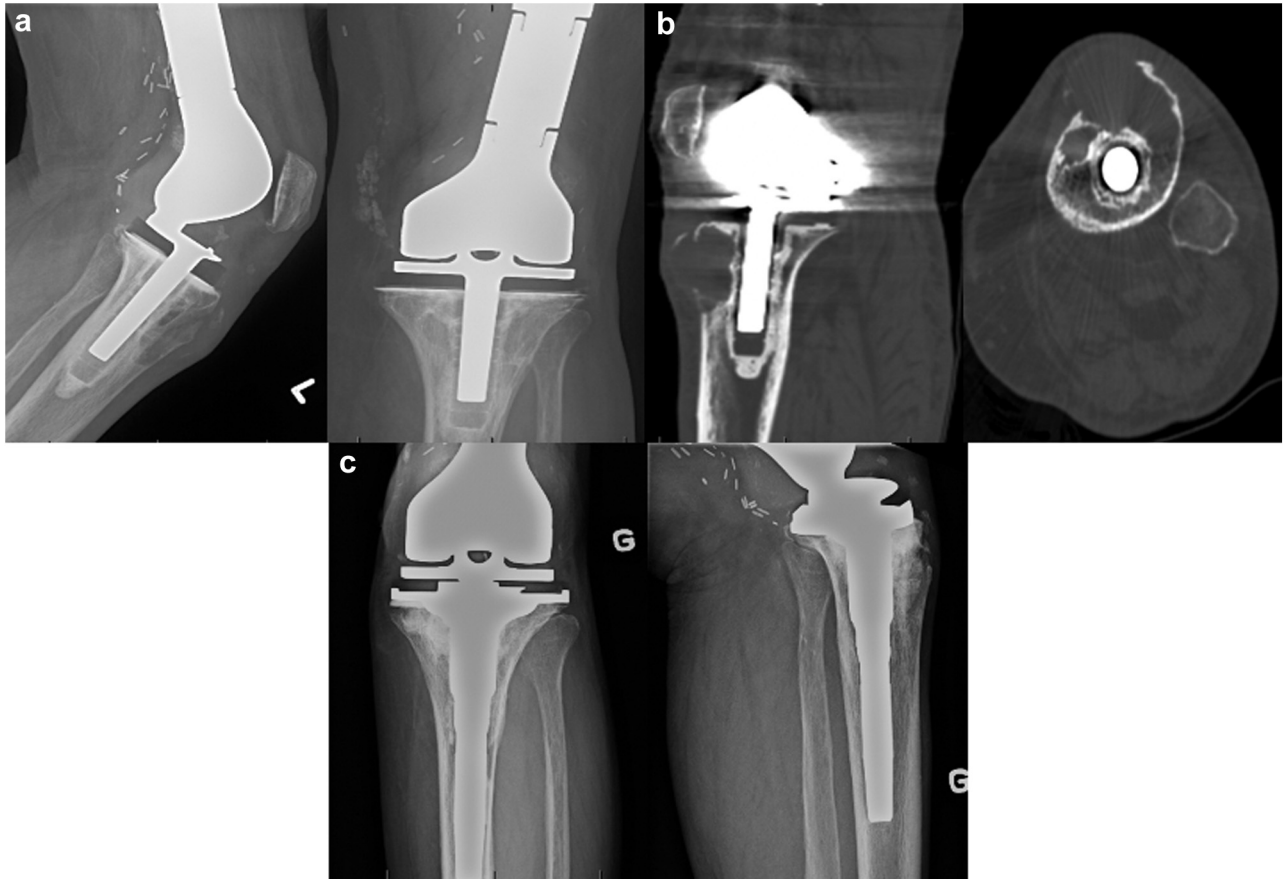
Patient B, left knee. (a) Plain radiographs demonstrating a nondisplaced fracture of the tibial tubercle and a progressive osteolysis. (b) CT images demonstrating periprosthetic osteolysis with a soft-tissue mass breaching the anterior cortex. (c) Plain radiographs 3 and a half years after curettage of the granuloma, revision of the all-polyethylene tibial component to a long press-fitted stem with cemented base plate and impact grafting of the proximal tibia.
